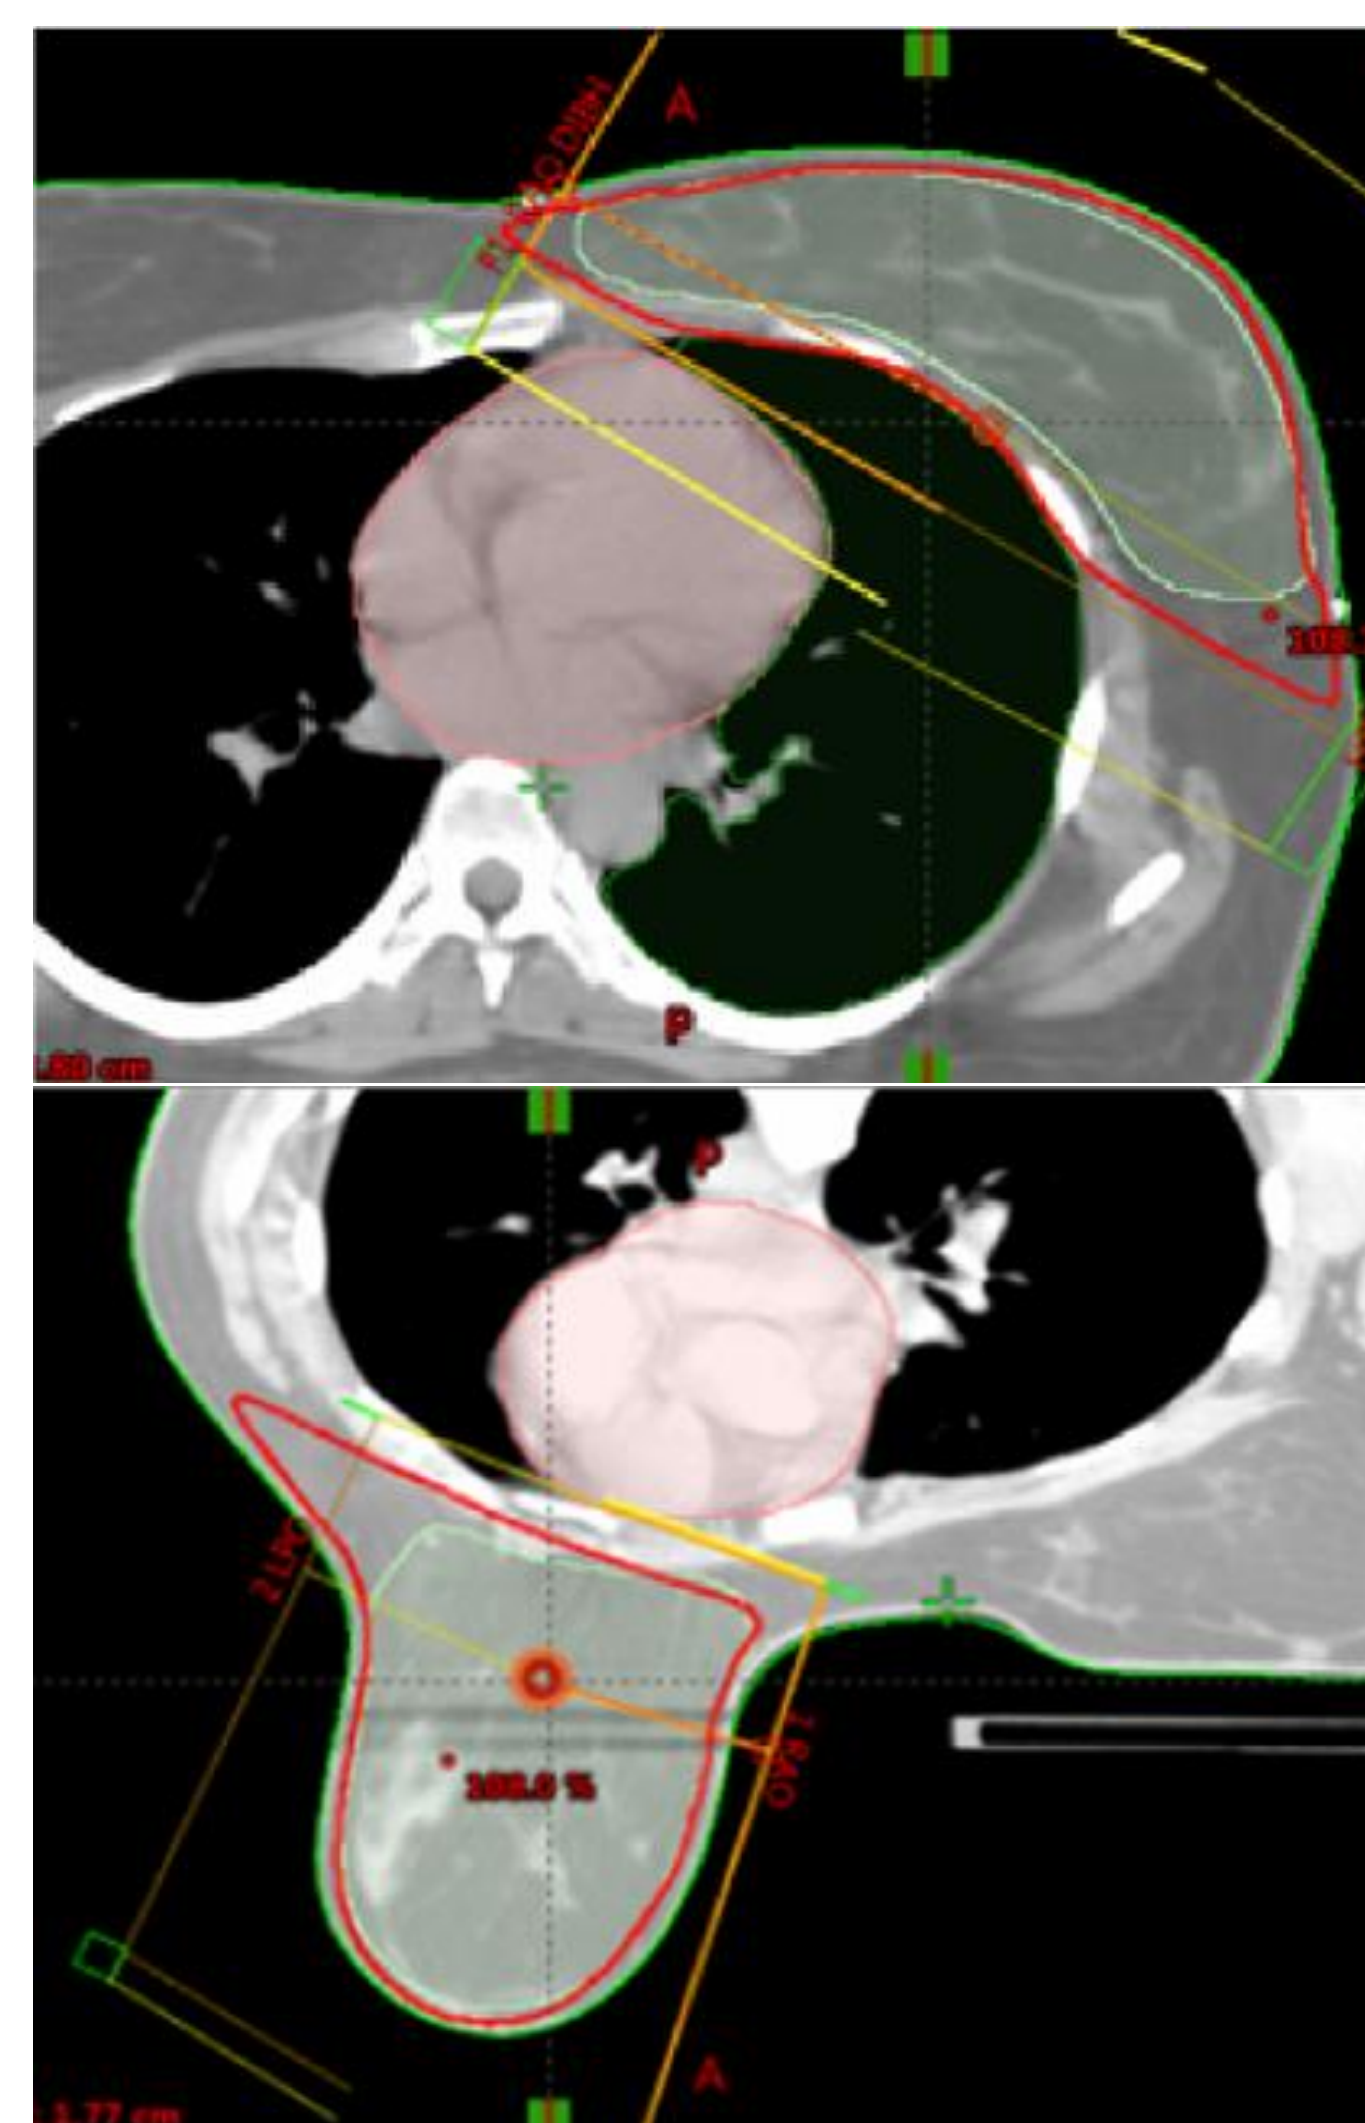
(top): Example of supine setup on CT slice with target volume and heart contoured (Saini et al., 2018, p. 4).
